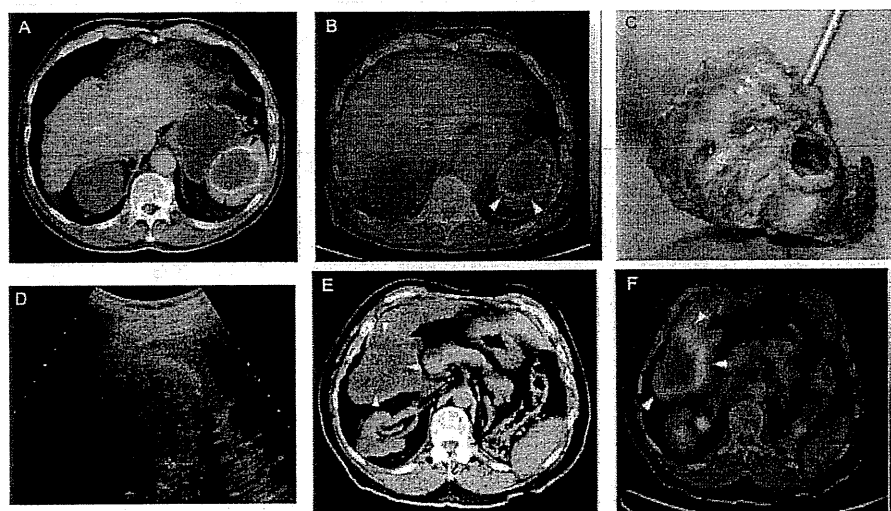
Recurrence of AE in the liver and spleen after LT for AE in (A,B) patient 2, (C) patient 5, and (D-F) patient 4. (A) Abdominal CT scan: calcification at the periphery of a large splenic AE lesion (arrowheads) 15 years after its discovery. (B) Combined FDG-PET/CT scan: no FDG uptake by the spleen lesion (arrowheads) and no AE lesions in the liver 20 years after LT. (C) Macroscopic image of a recurrent AE lesion during surgery 14 years after LT. (D) US examination: hyperechogenic AE recurrence (cross) in the liver 6 years after LT. (E) Unenhanced abdominal CT scan: hypodense recurrent lesion in the right lobe of the liver (arrowheads) 6 years after LT. (F) Combined FDG-PET/CT scan: high perilesional FDG uptake by the liver (arrowheads) 16 years after LT.
